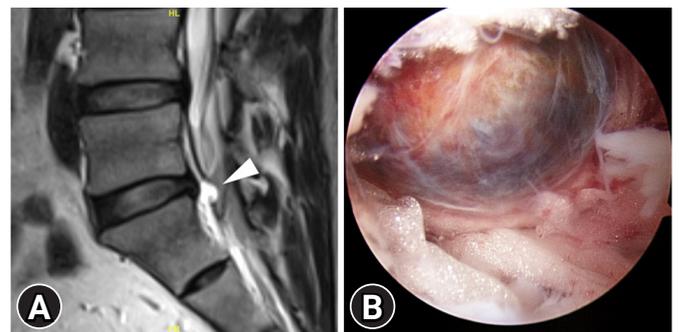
(A) MRI of the lumbar spine showed a cystic mass (white arrow head) mimicking a ruptured disc herniation at L5-S disc level with posterior displacement of the S1 traversing nerve root. (B) Intra-operative photo showed a well-capsulated brownish blue cyst beneath the traversing nerve root.
